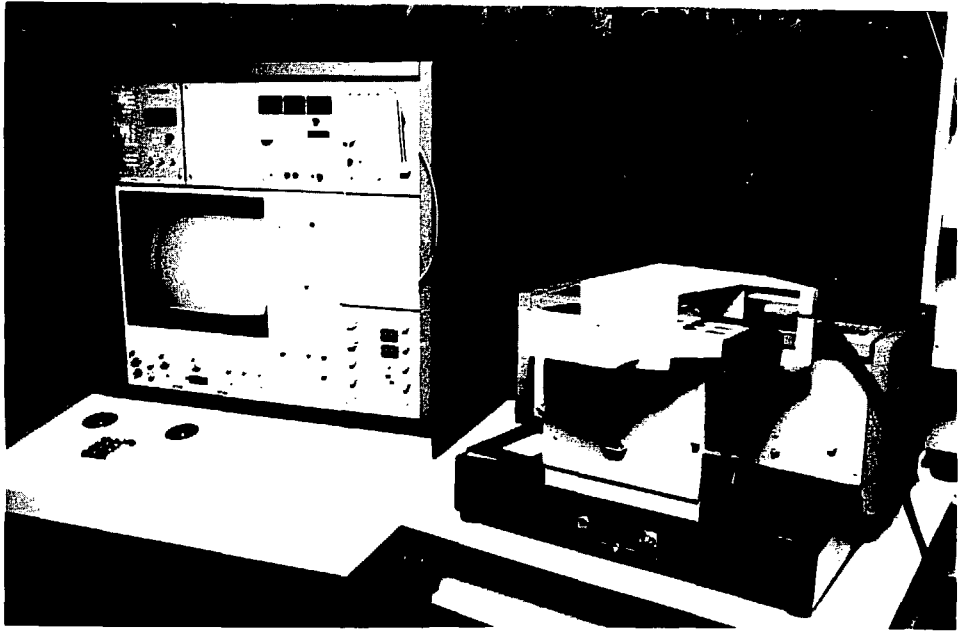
Epidiascope and Quantimet 720-D for scanning the intraoral radiographs.
